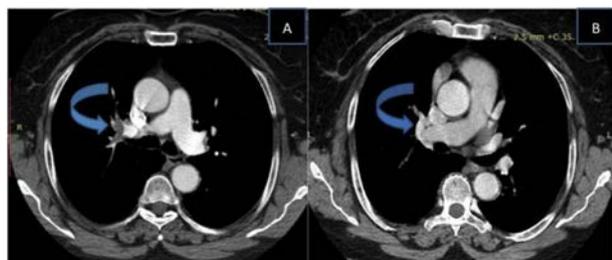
CT showing filling defects in pulmonary arteries (A) and normal appearance after treatment (B).
